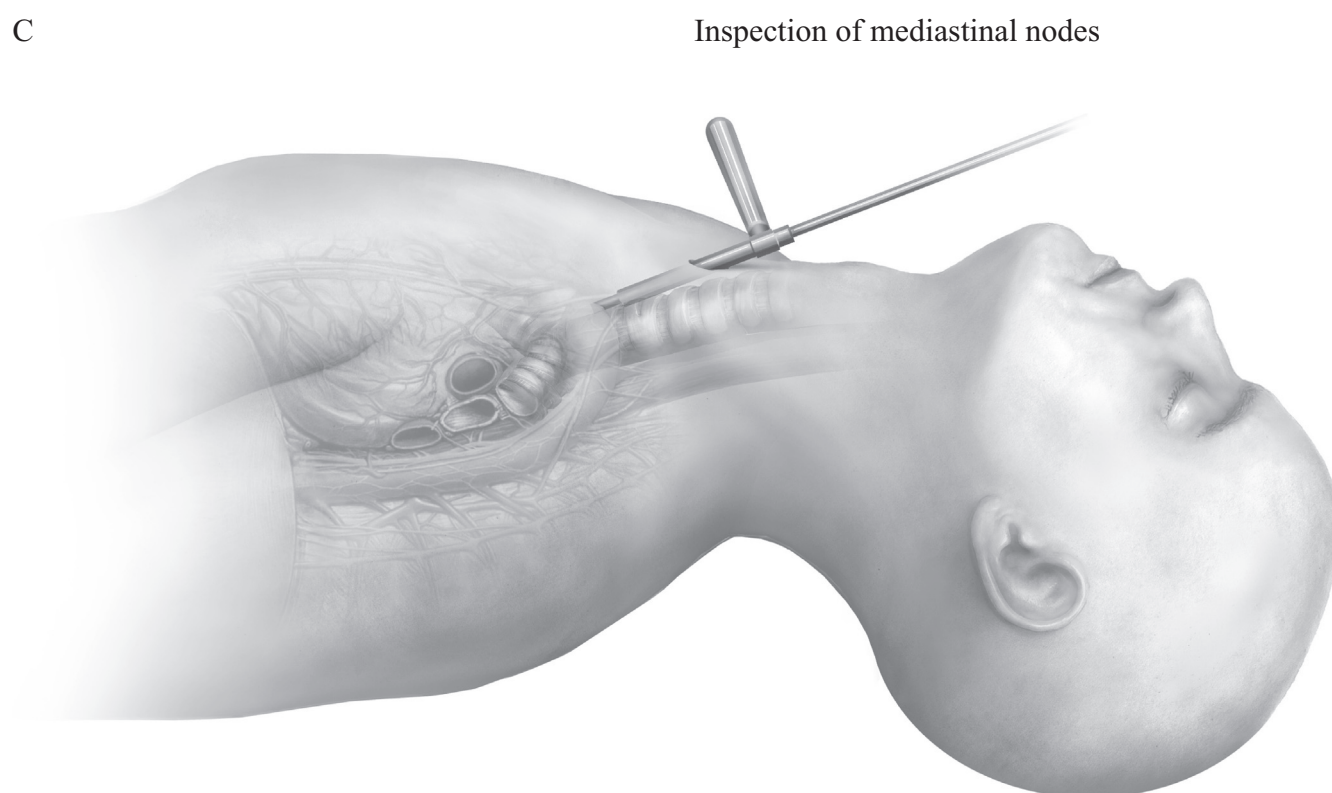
(Continued) which uses ultrasound to visualize suspicious paratracheal lymph nodes, or via cervical mediastinoscopy (C).
